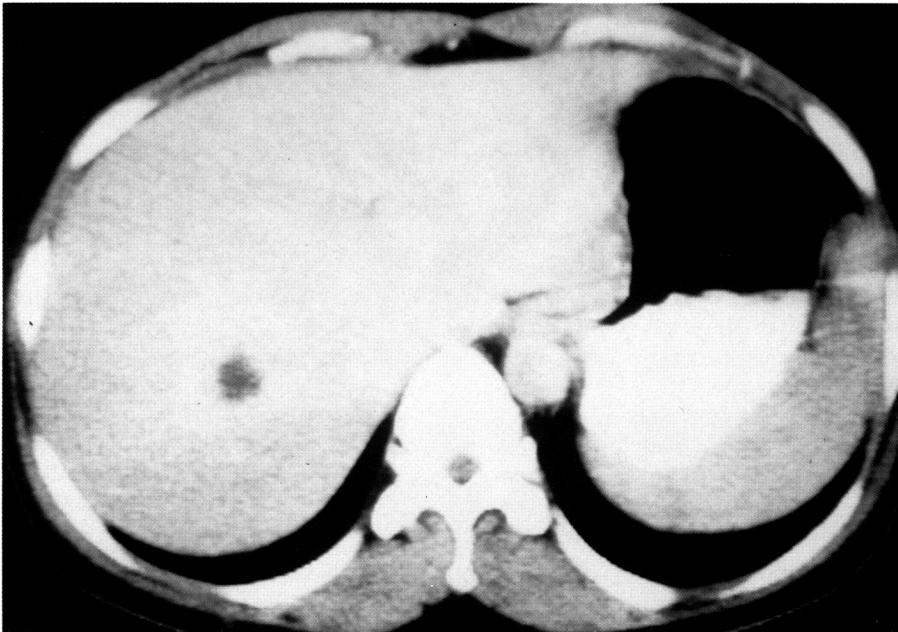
Contrast-enhanced CT scan of the abdomen disclosed a strongly enhancing mass except for the central area.
